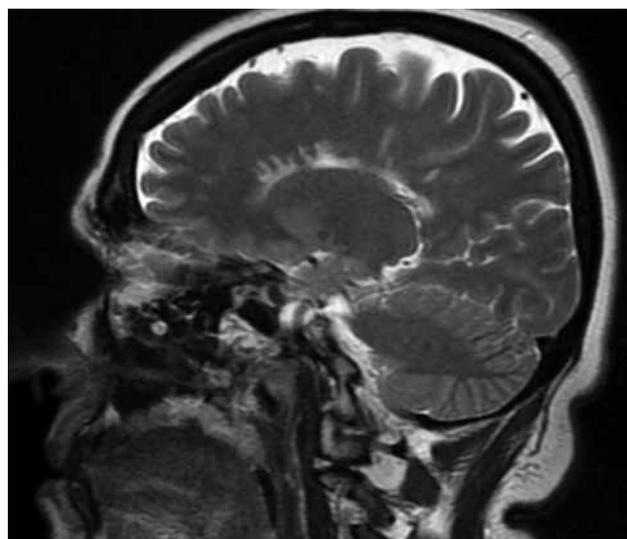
A T₂-weighted magnetic resonance imaging of a patient showing a high-signal lesion in periventricular area.
